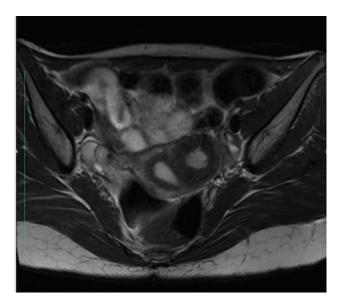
Contrast MRI axial section showing accessory non communicating cavity.
